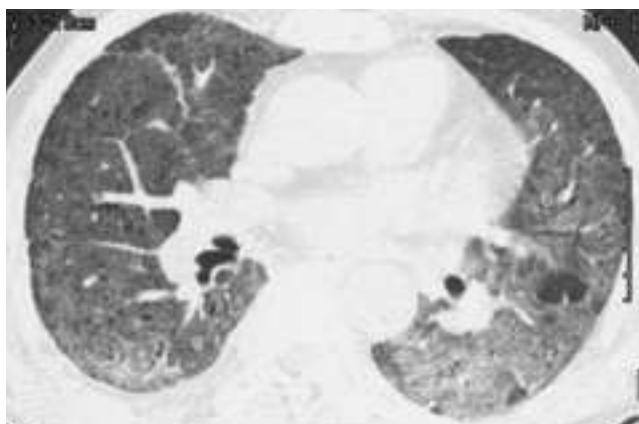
On HRCT, diffuse ground-glass opacity was noted in both lung and irregular linear opacities were present in subpleural portion of both lower lobe.
